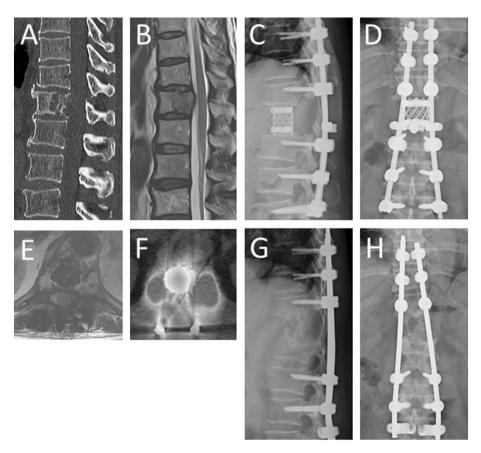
Pre- and postoperative images. Preoperative multiplanner reconstruction sagittal image of computed tomography revealed osteolytic lesion at 12th thoracic vertebra (A). Magnetic resonance image (MRI) revealed tumor protruding to spinal canal (B). Total en bloc spondylectomy via single posterior approach was performed (C, D). Tumor was gloss totally resected. One year after primary surgery, deep surgical site infection occurred (MRI: E, positron emission tomography: F). Therefore we removed the infected cage followed by autologous iliac bone grafting (G, H).
